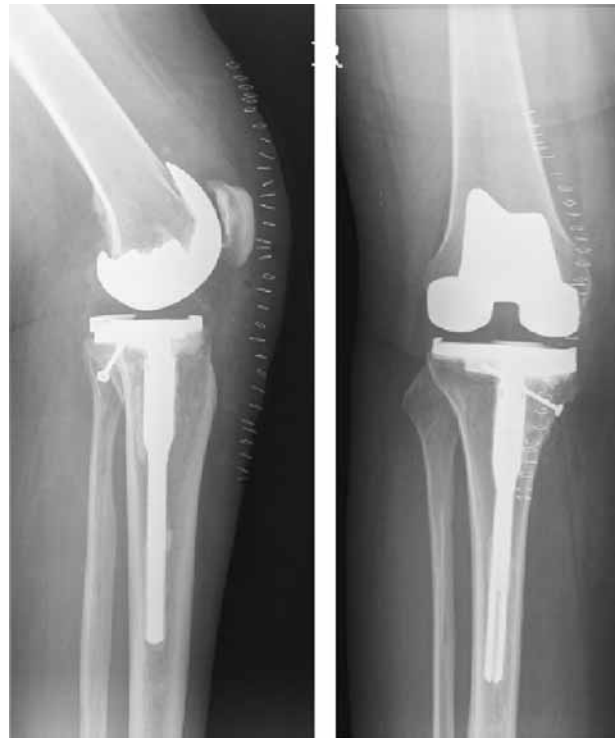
Radiographs after revision TKA show good position and alignment of the prosthesis. No signs of loosening (Case 2).
